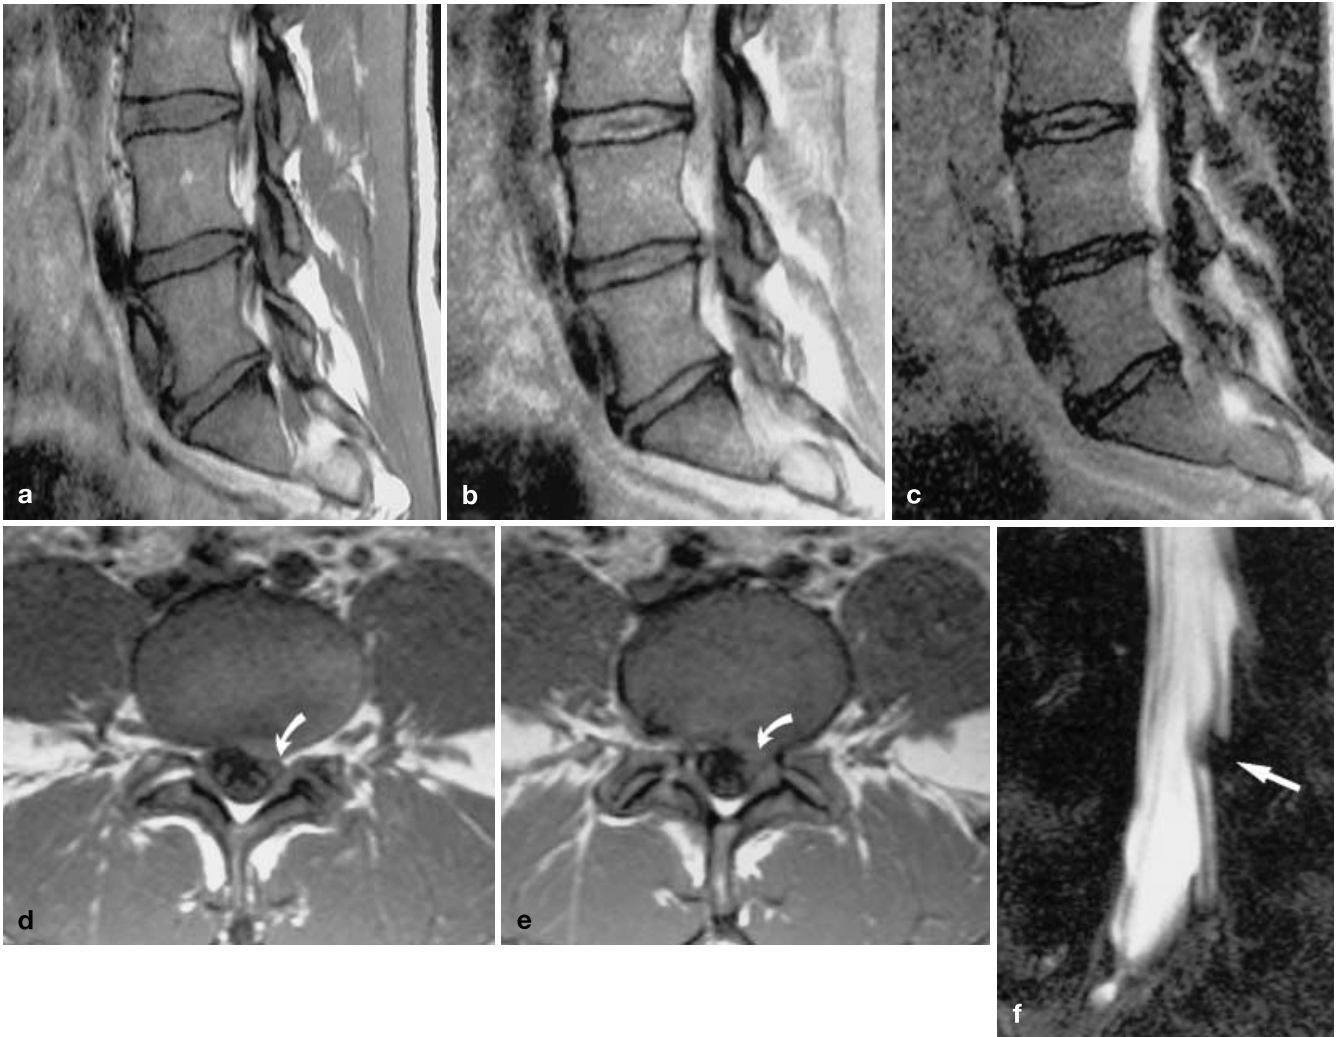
MR imaging assessment
